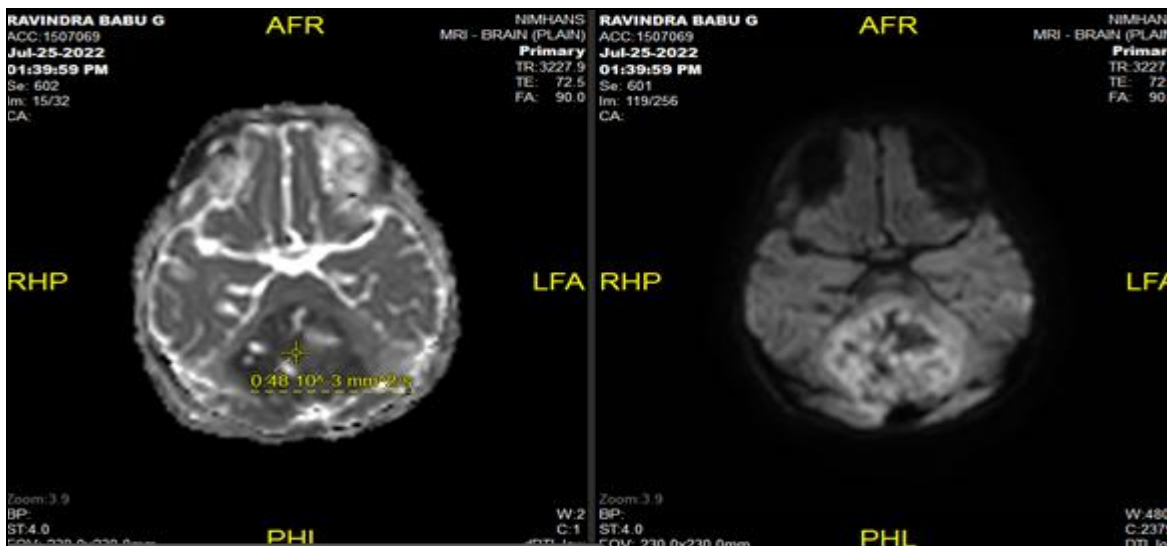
DWI AND ADC IMAGES IN A CASE OF 1 YEAR OLD GIRL WITH ATRT SHOWING DIFFUSION RESTRICTION AND LOW ADC VALUE ( $0.64 \times 10^{-3}$ ). ATRT MIMICS MEDULLOBLASTOMA DUE TO ITS CENTRAL LOCATION IN POSTERIOR FOSSA AND ITS HIGHLY CELLULAR AND HETEROGENEOUS NATURE
